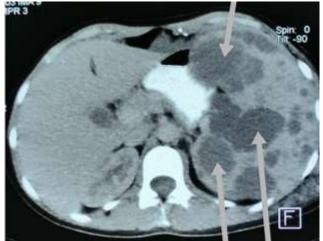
Axial abdominal CT scan showing a multicystic splenomegaly.
